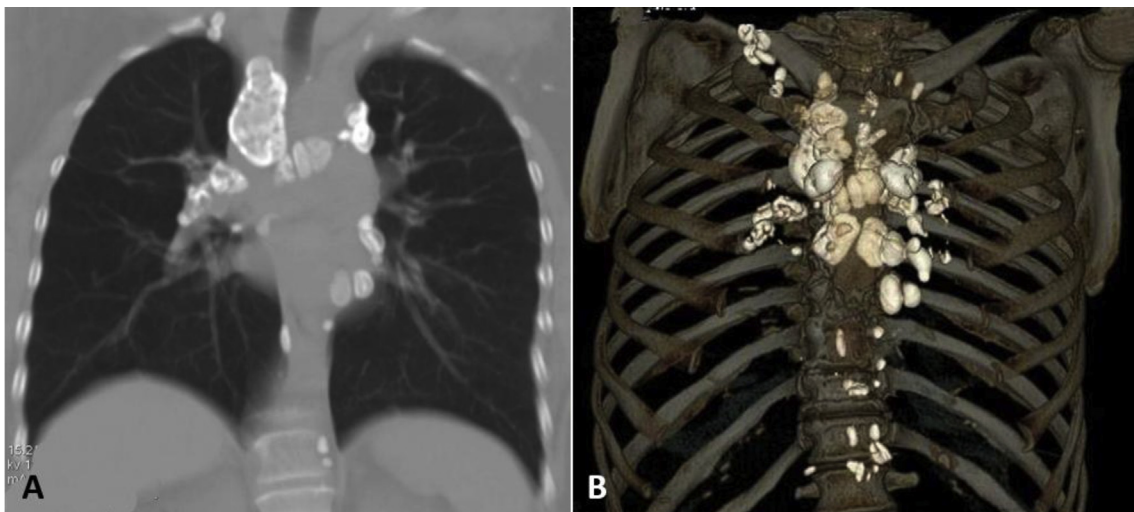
Images from a 62-year-old male coal worker presenting with chronic cough and dyspnea. Note the extensive eggshell-like lymph node appearance at all stations on the coronal CT reconstruction (A) and 3D volume rendering (B). An open lung biopsy confirmed the diagnosis of silicosis.
